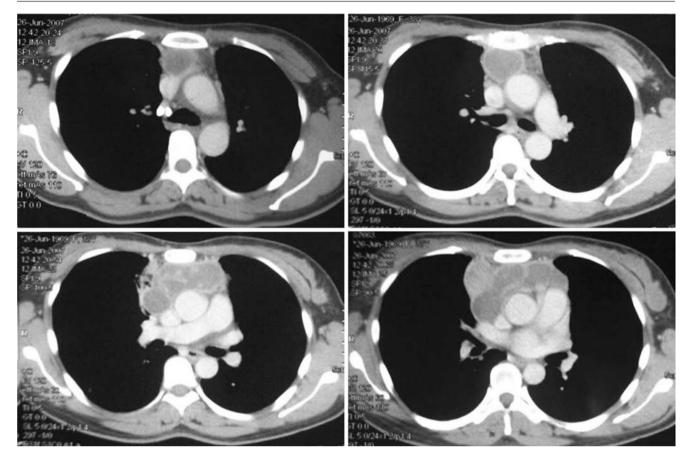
Chest CT images of a 38-year-old man complained of paroxysmal chest pain and tightness for more than half a month
